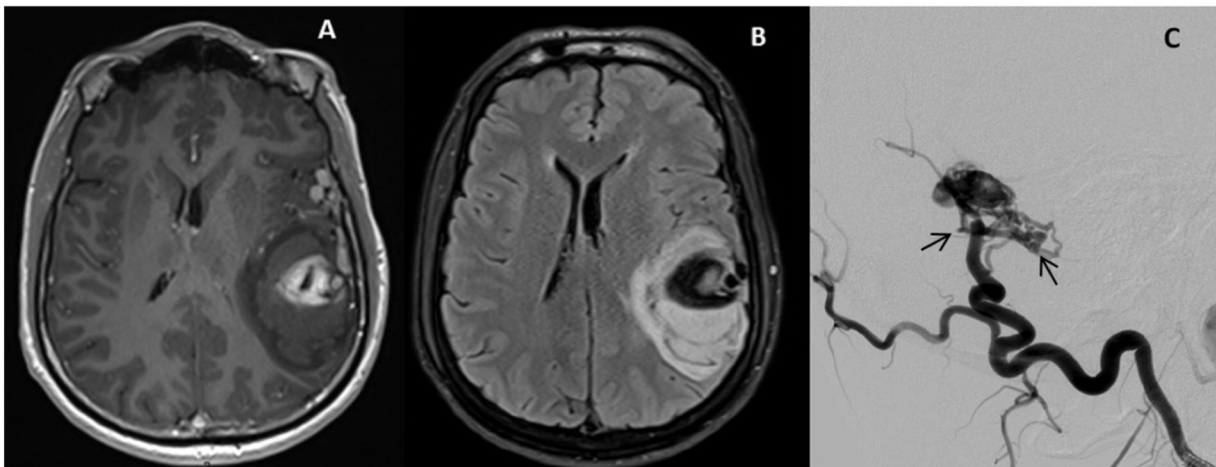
(A), T1-weighted with gadolinium enhanced and (B) FLAIR weighted MRI images showing a left temporal hemorrhage associated with a mass effect with compression of the left lateral ventricle. (C), Arteriography showing a type IV DAVF with venous ectasias (arrows).
